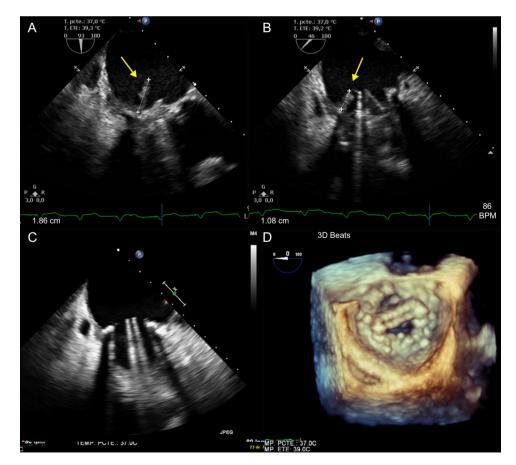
Transesophageal echocardiography. A and B: endocarditic vegetation on mitral prosthetic valve. C: postsurgical transesophageal echocardiography, 90° view; the mitral prosthetic valve shows no signs of infective endocarditis. D: 3-dimensional echocardiography using zoom (*en face*).
